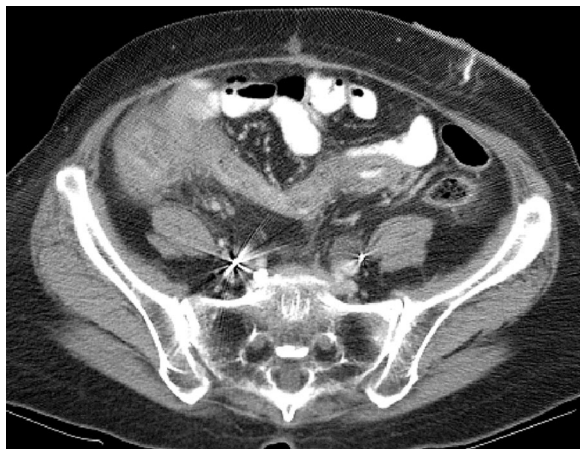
Typhlitis (neutropenic colitis). Contrast-enhanced CT scan demonstrates a shaggy cecum and inflammation of the cecum and terminal ileum.
